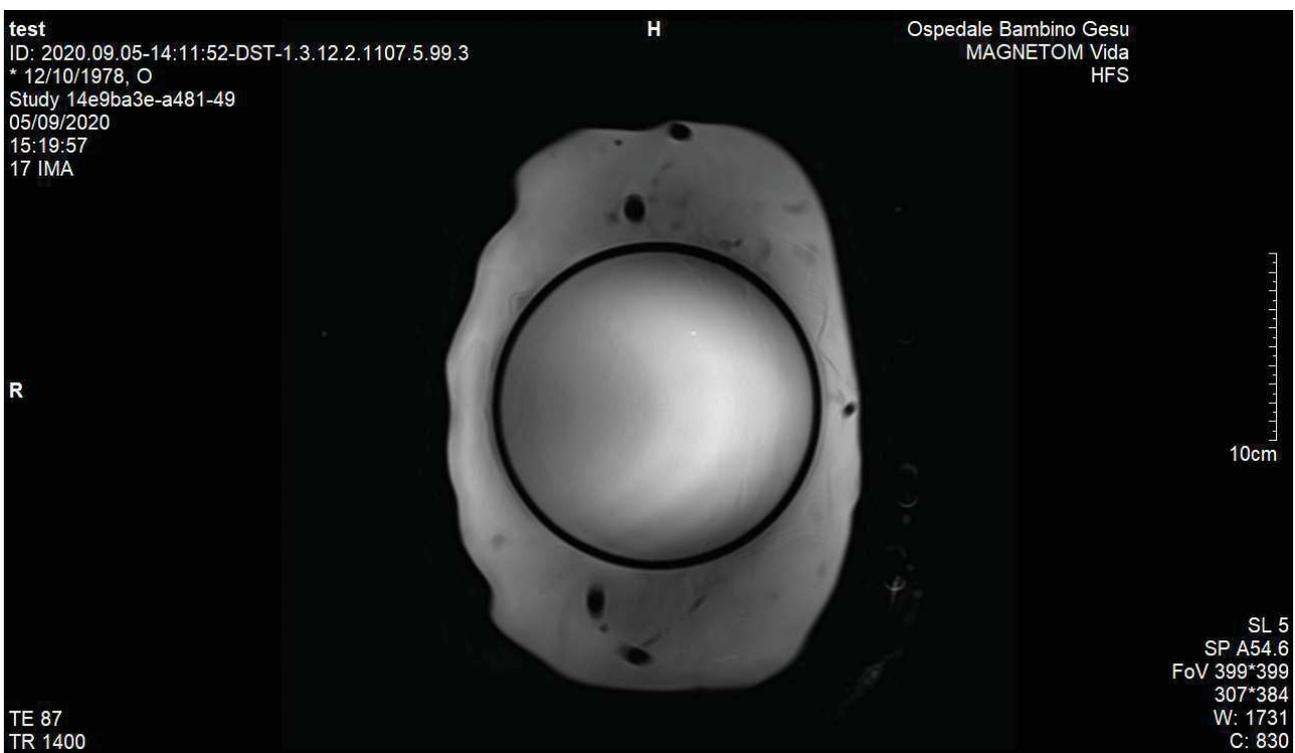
MRI scanned image
